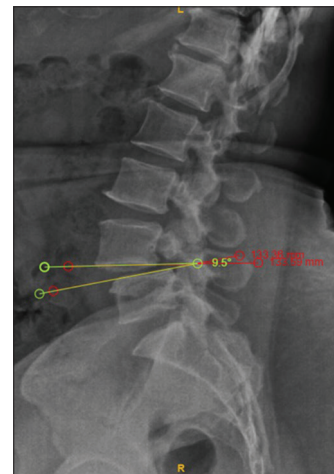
(a) Anteroposterior and (b) lateral radiographs of the lumbosacral spine. In the lateral view, the head of femur should be included
